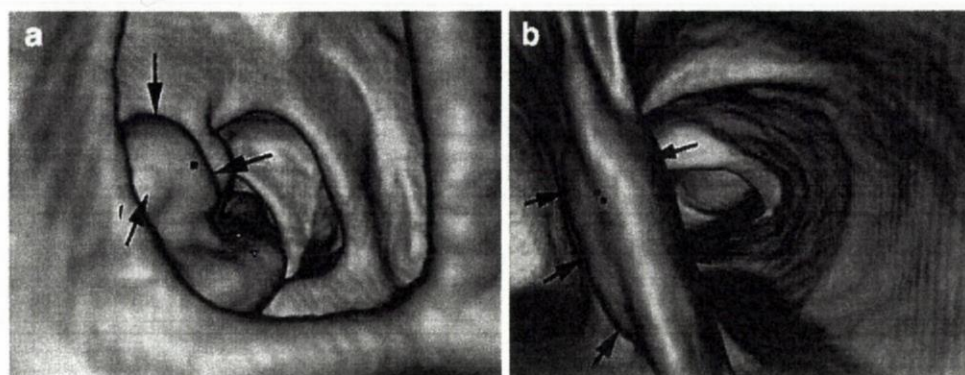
a 3D endoluminal CT colonographic image showing a CAD-detected type 0-IIa+IIc T1 ascending colonic carcinoma (arrows). The CAD detection (red dot) was classified as "focal" as located on a recognizable focal elevation. Yellow triangles represent further
